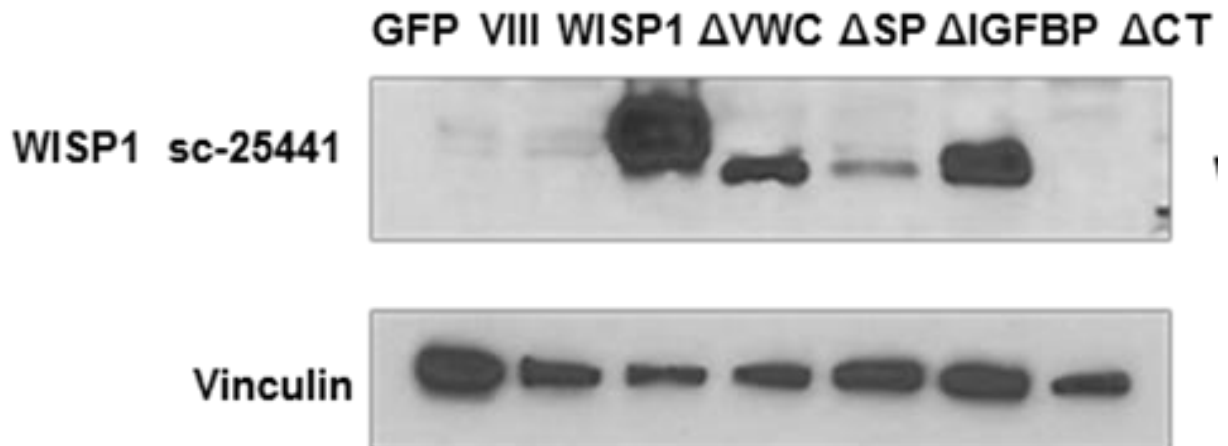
Immunoblots from lysates of the resulting U87MG subcutaneous tumors expressing each truncated form and the controls (GFP, EGFRvIII, WISP1). Again two different antibodies were used since the Δ CT WISP1 is not picked up by the antibody that recognizes an epitope from amino acids 311-367 (sc-25441) while the Δ VWC WISP1 is not picked up by the antibody that recognizes an epitope from amino acids 135-230 (ab155654). .
